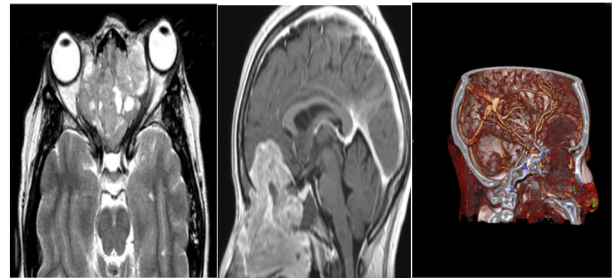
T1 Gd-enhanced MRI showing a solid lesion originating in the cribriform plate that invaded the anterior cranial fossa, upper ethmoidal cells, nasal cavity, nasopharynx and the maxillary sinuses.
